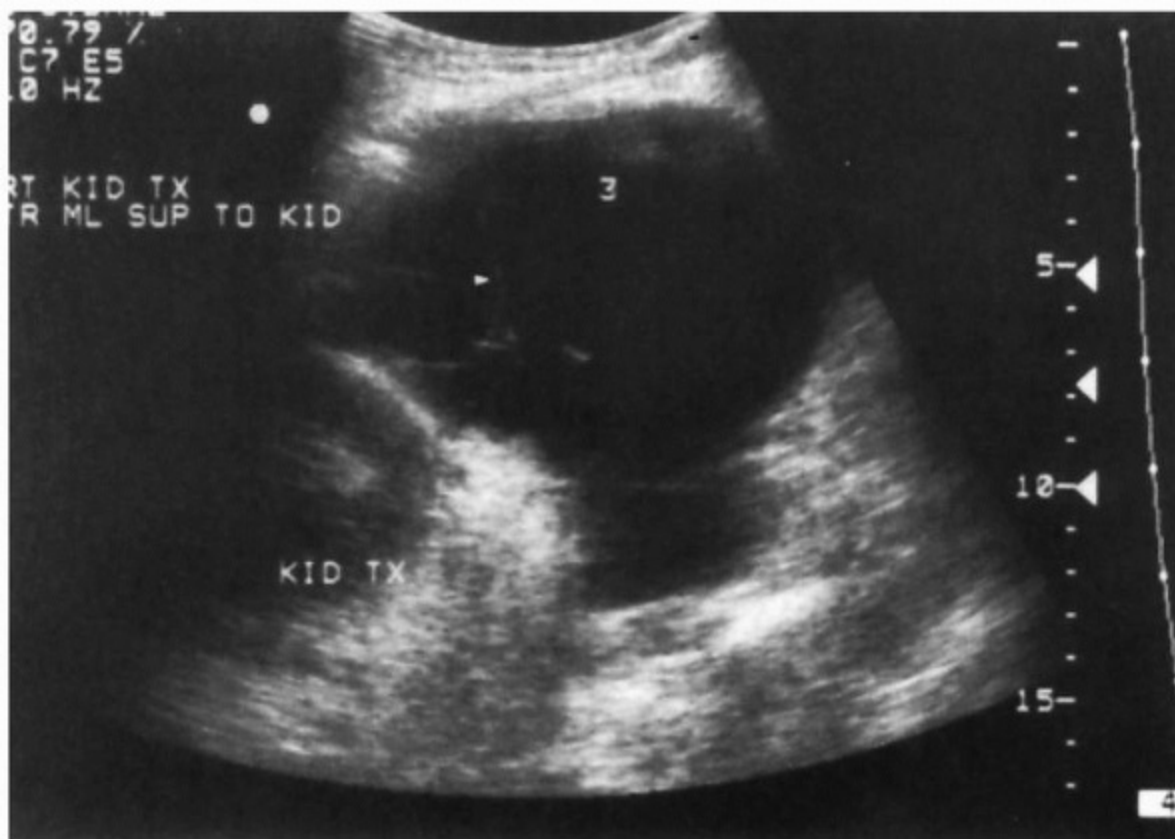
Sonogram demonstrating lymphocele (3) with septations (*arrowhead*).
